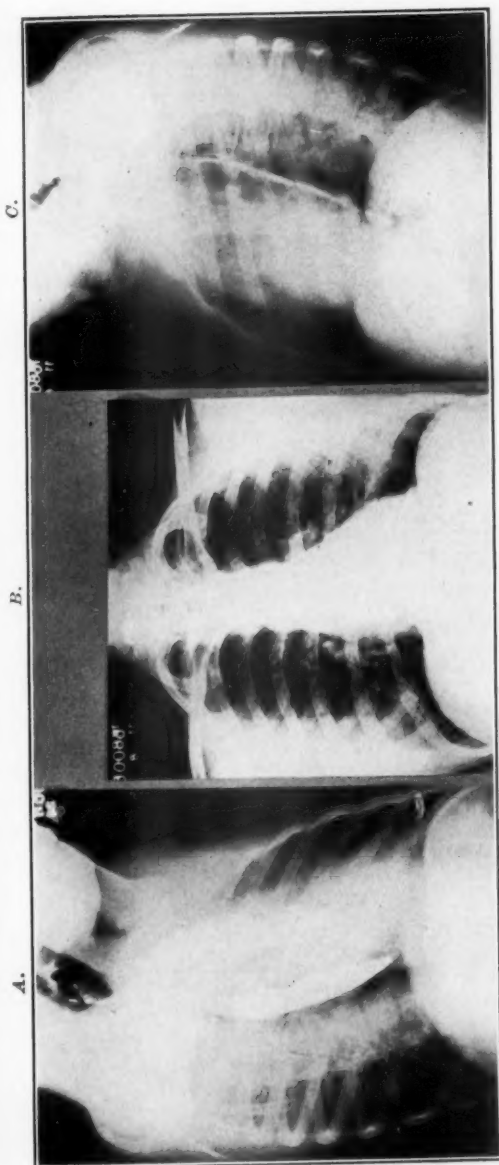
A normal heart, radiographed in the right anterior oblique position (A), the postero-anterior position (B), and the left anterior oblique position (C). L.A., left auricle; L.V., left ventricle; R.V. (I.T.), right ventricle, inflow tract; R.V. (O.T.), right ventricle, outflow tract; O.P., oscillating point (the point of opposite pulsation between the right ventricle and left ventricle at the junction of the second and third left cardiac arcs; I.I.N., inferior interventricular notch between the left ventricle and inflow portion of the right ventricle; A.A., ascending aorta; D.A., descending aorta.
